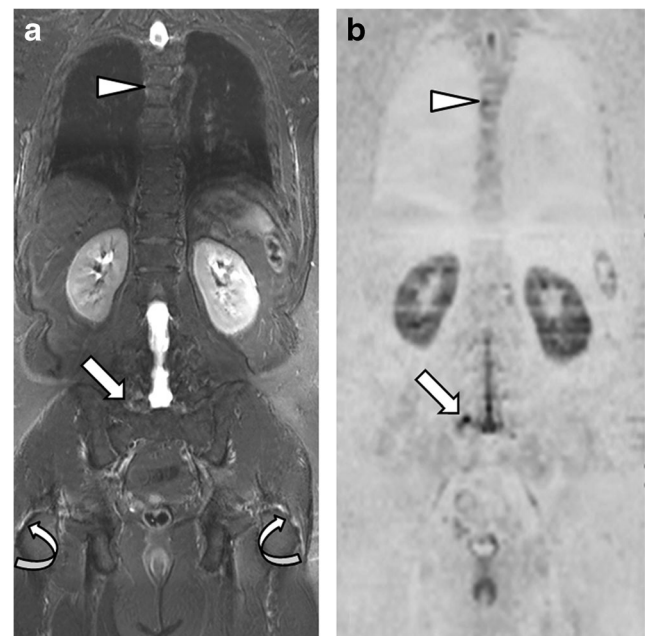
63-year-old male with negative WB MRI screening for prostate cancer metastases, included in the control population. Comparison of STIR (A) and DWI (inverted grey scale) (B) whole body MRI sequences. Degenerative involvement of the thoracic spine (arrowheads) and of a right posterior (zygapophyseal) joint within the lumbar spine involvement (arrows) is visible on both images. Note that involvement of tendinous insertions on the greater trochanter is visible only on STIR images (curved arrows in A), not on DWI
